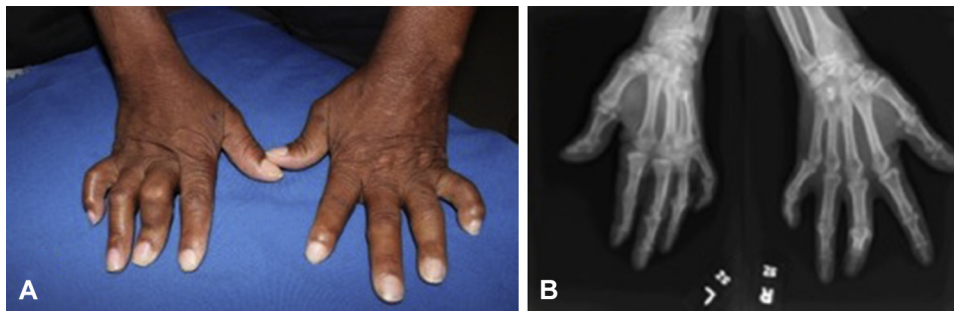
Erosive arthropathy. A, Bilateral finger swellings and deformities. B, Pencil-in-cup deformities noted on x-ray.
